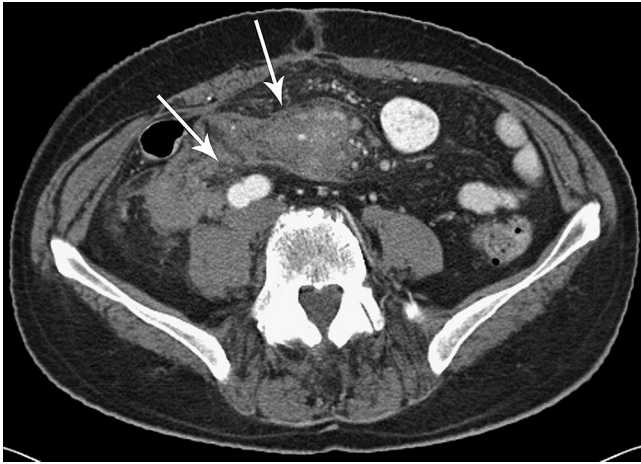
Gastrointestinal basidiobolomycosis in a 66-year-old man. Computed tomography of the abdomen shows a large mesenteric mass (*arrows*) that obstructs the right ureter (not shown).
